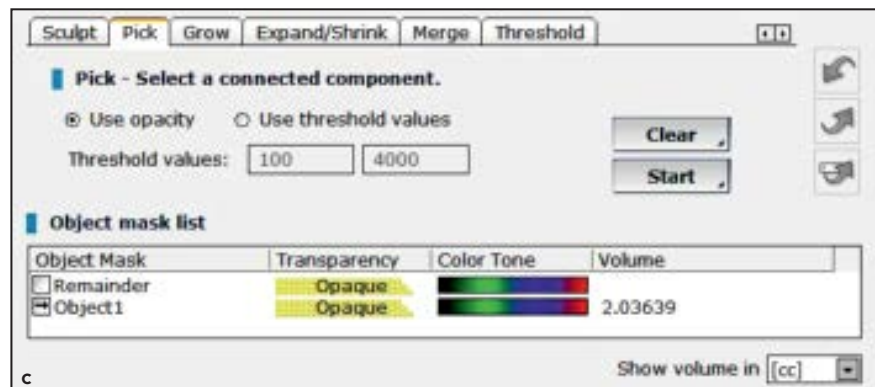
Sequence of the grafted material volume calculation using opacity after CBCT scan subtraction.
